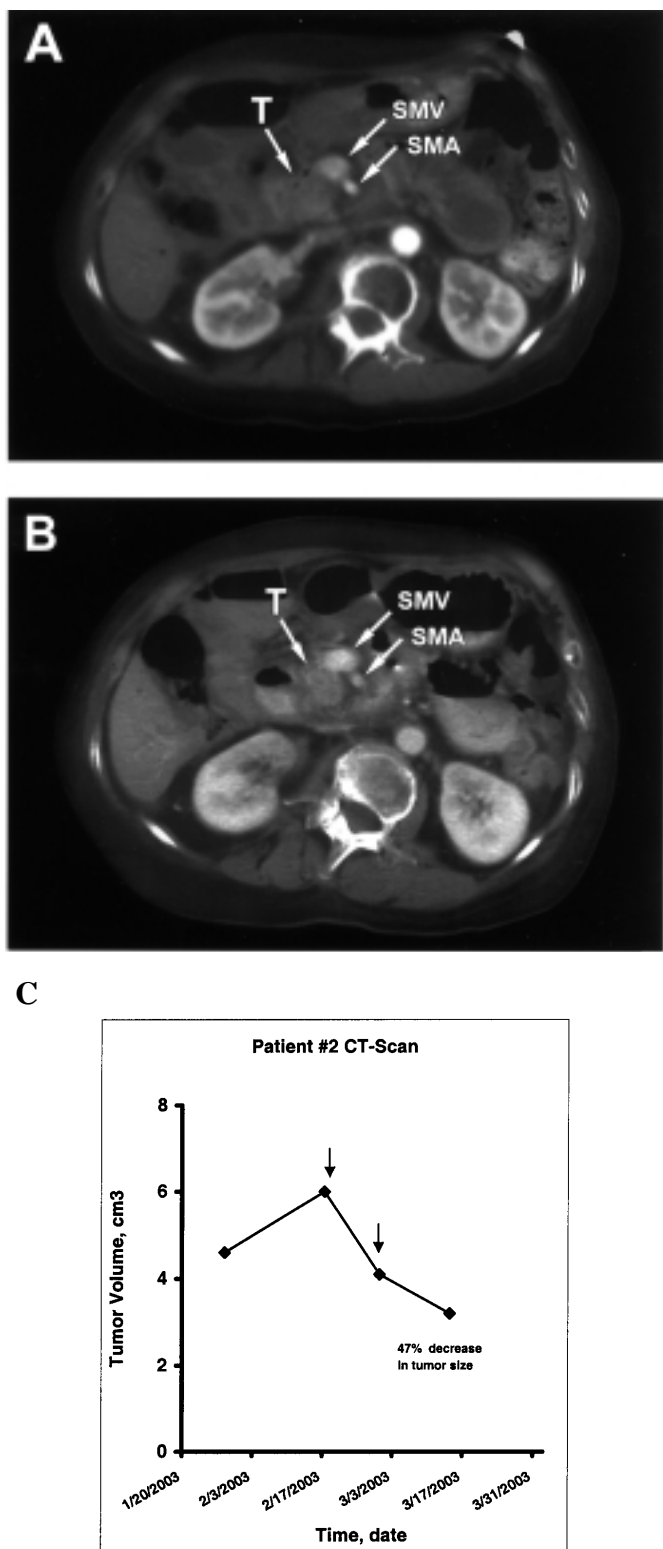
(A), Representative abdominal CT scan from patient #2 obtained at the beginning of treatment cycle #1 revealing a 6.0 cm³ mass in the region of the pancreatic head (T) encroaching on the superior mesenteric vein (SMV) and the superior mesenteric artery (SMA). (B), Follow-up abdominal CT scan from patient #2 two days after completion of treatment cycle #2, revealing that the pancreatic tumor mass (T) has decreased in size and regressed away from the superior mesenteric vessels (SMV and SMA). The start of each treatment cycle is indicated by arrows. (C), Regin-G arrests primary tumor growth in patient #2. A progressive decrease in tumor size was noted with successive treatment with Regin-G. Tumor volume (cm³) derived by using the formula: width² x length x 0.52 (16) and plotted on the vertical axis, is expressed as a function of time, plotted on the horizontal axis. The start of each treatment cycle is indicated by arrows.
